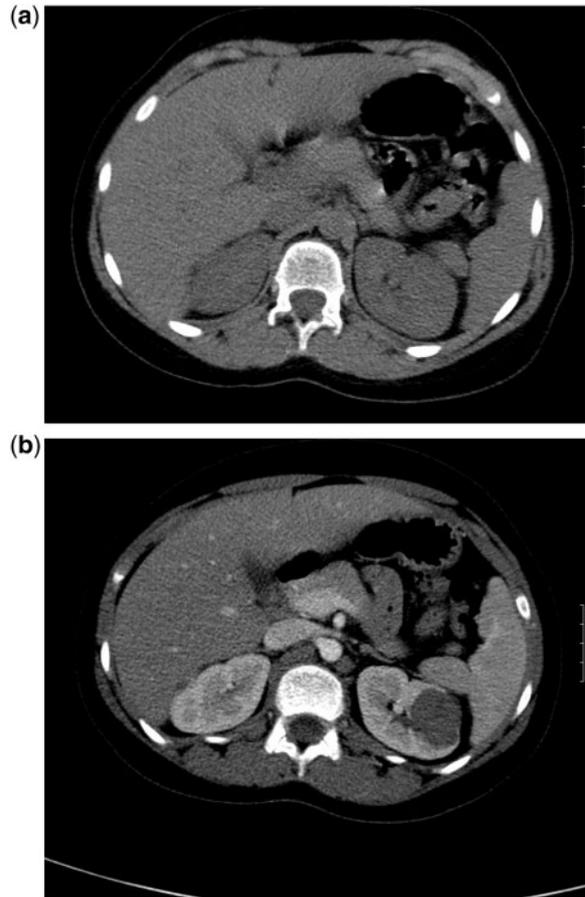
(a) Non-contrast CT of a suspected mass lesion in the left kidney of an 8-year-old girl, discovered with ultrasound, is essentially normal. (b) Post-intravenous contrast-enhanced CT of the same patient on the same day shows an obvious mass lesion in the left kidney, proven later to be a Wilms tumour (nephroblastoma). The non-contrast study was of no diagnostic benefit here.
